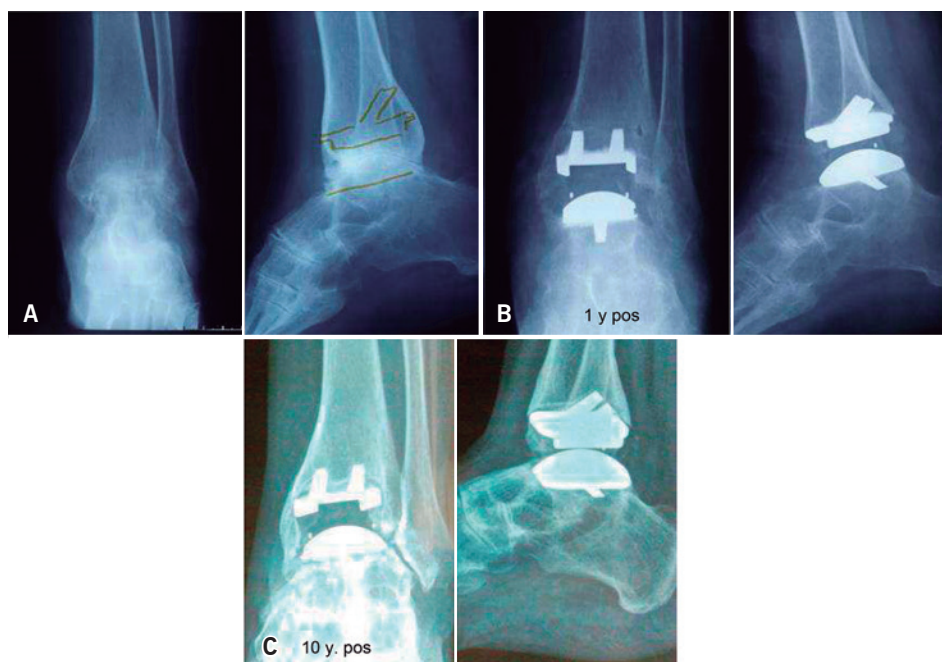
Male, 32 years old, ankle OA secondary to tibial fracture. Surgery 2001. Change of polyethylene liner and Achilles tendon lengthening at 1 year due to stiffness. Last control at 10 years in 2011. Normal daily living. Abandons climbing. Moderate functional limitation and pain; A) Preoperative X-ray; B) Post-operative X-ray; C) X-ray 2011 at 10 years. Metaphyseal widening and joint space narrowing are noticed
